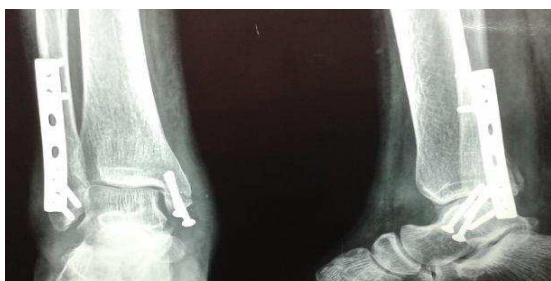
Antero-posterior and lateral view radiograph at union 10 week
